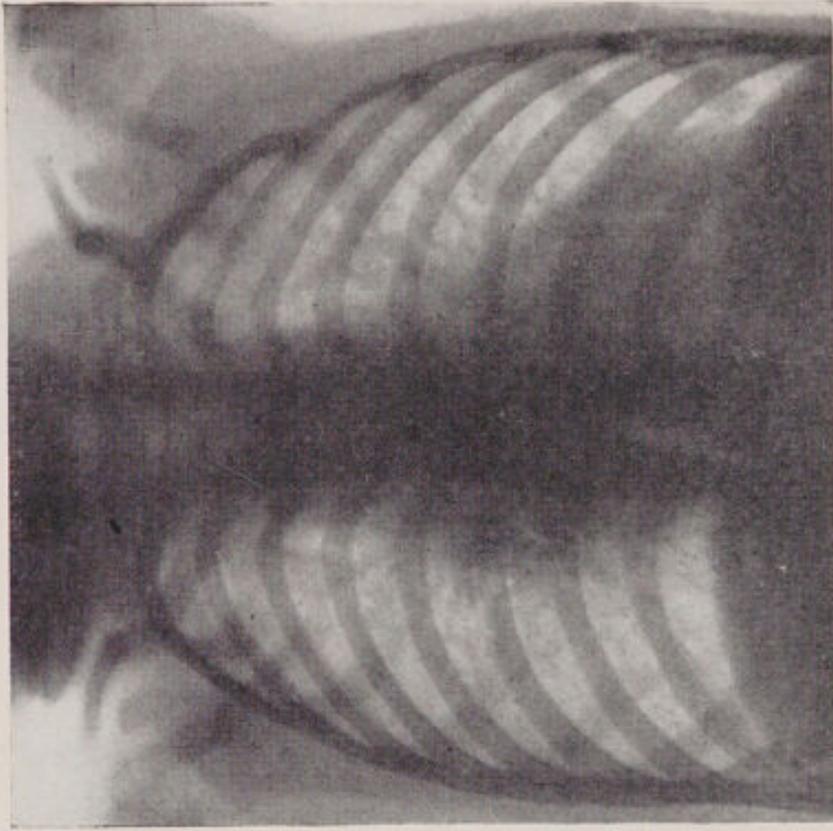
Oct. 17, 1937; aged 3 years and 4 months. Lungs clear; osseous lesions and abscesses healed; sent to an orphanage. One year later chest radiograph the same. Feb. 10, 1940; aged 5½ years. Mors from generalized tuberculosis, with recurrence of skin abscesses; chest not X-rayed.
